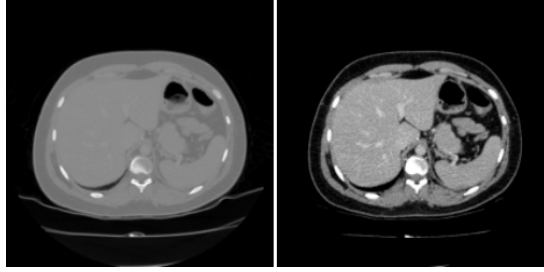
Original raw input CT slice (on the left), and after the enhancement process (on the right).
